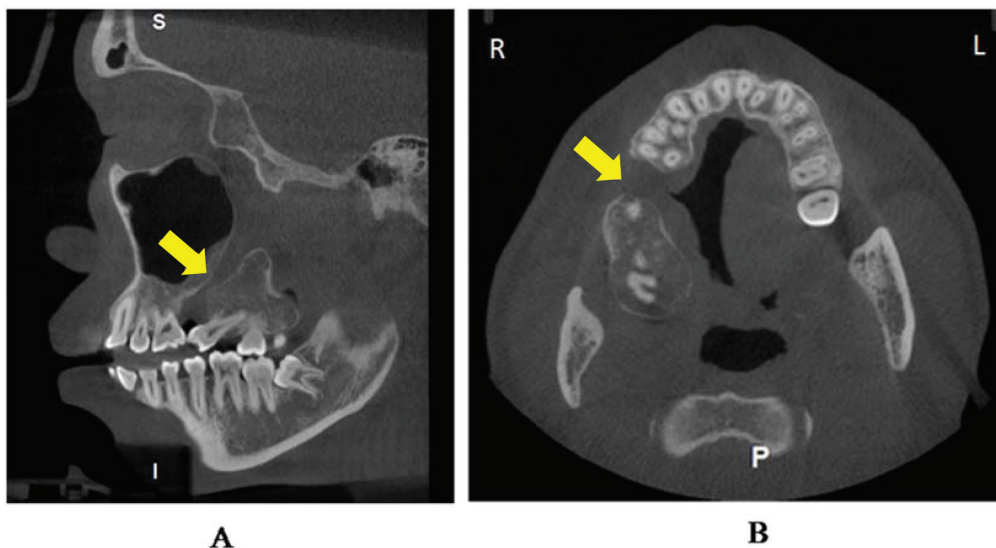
Sagittal (A) and Axial (B) views of CBCT scan showing separation of the right maxilla
